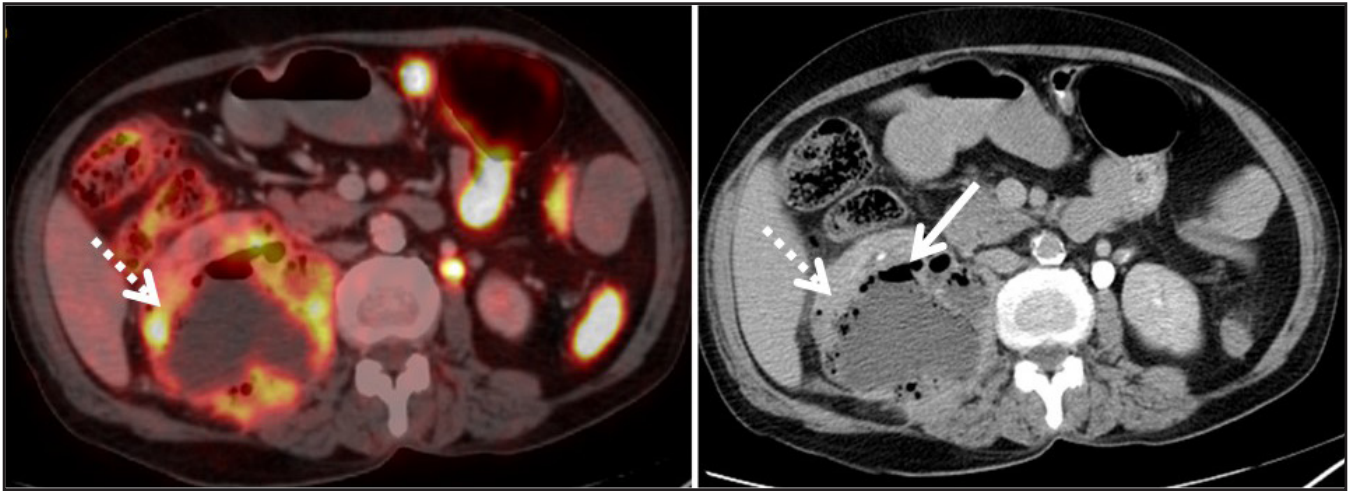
(a): Axial PET/ CT images of abdomen demonstrating hypodense abscess cavity in the postero inferior part of right kidney with multiple pockets of air lucencies within (arrow) and FDG avid uptake in the peripheral enhancing part (dotted arrow).
